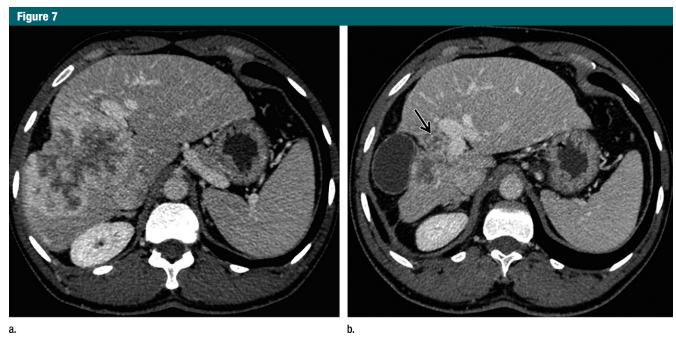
Axial contrast-enhanced CT images in a 39-year-old man with intrahepatic cholangiocarcinoma treated with selective intrahepatic radiation therapy (also called radioembolization). (a) Portal venous phase image shows the tumor in the right liver, which enhances over time. (b) Portal venous phase image obtained 18 months later shows tumor shrinkage (arrow) and right atrophy of the liver. Note the compensatory contralateral hypertrophy.
